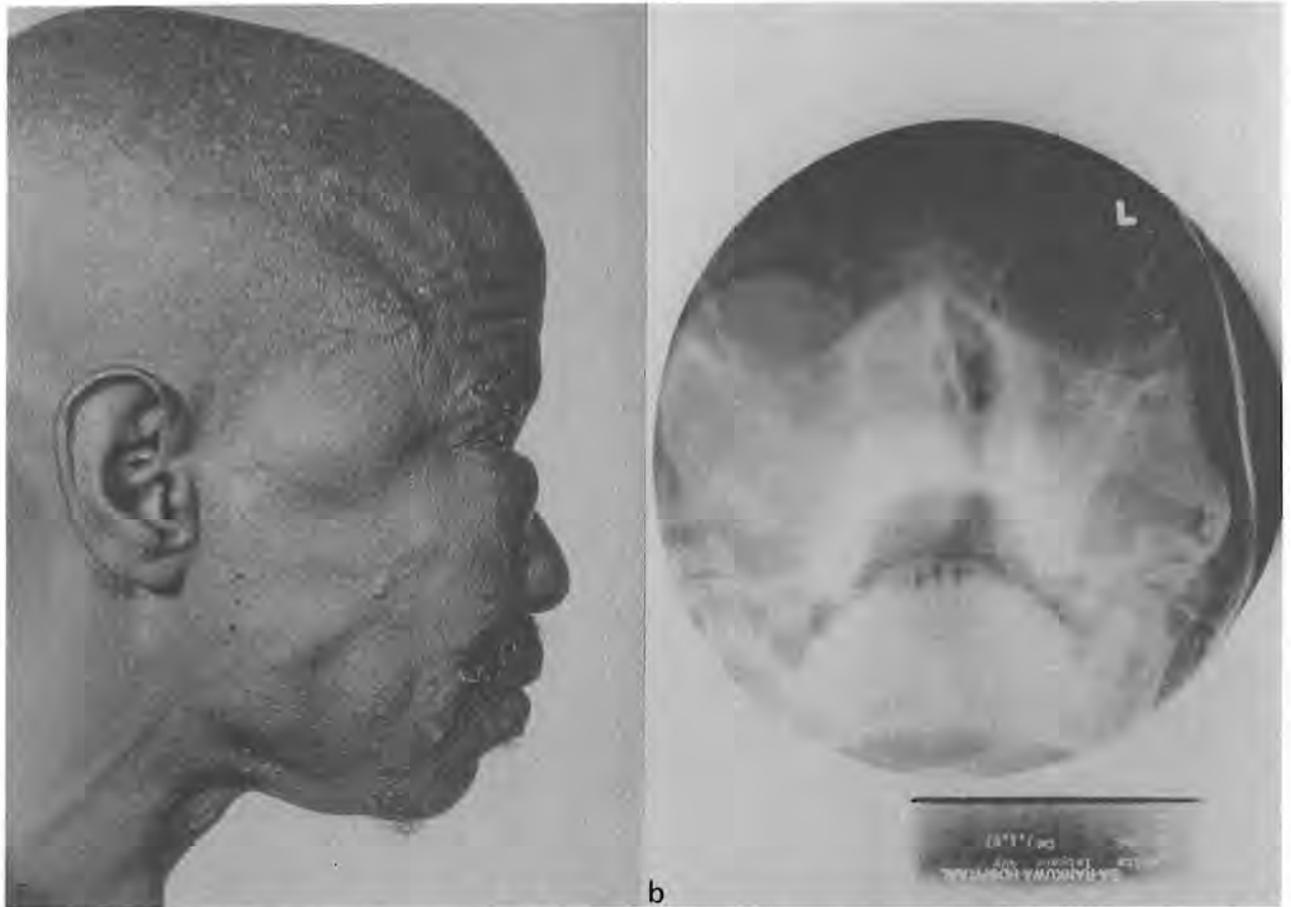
(a). 40-year-old male (case no. 1) with myelomatous tumours above the right zygomatic arch, beneath the orbit, lateral to the ala and overlying the zygomatic eminence. (b) Radiograph of the case depicted in (a), showing destruction of the right maxillary sinus, inferior orbital margin, zygoma and lateral wall of the nose.
